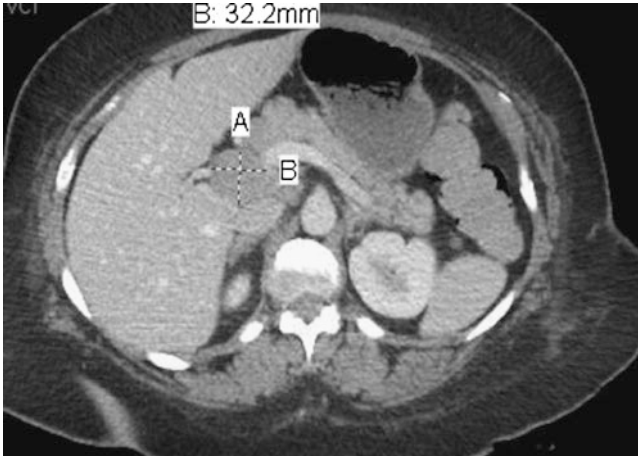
CT Abdomen showing enlarged portal lymph node which was selected for endoscopic ultrasound guided fine needle biopsy
